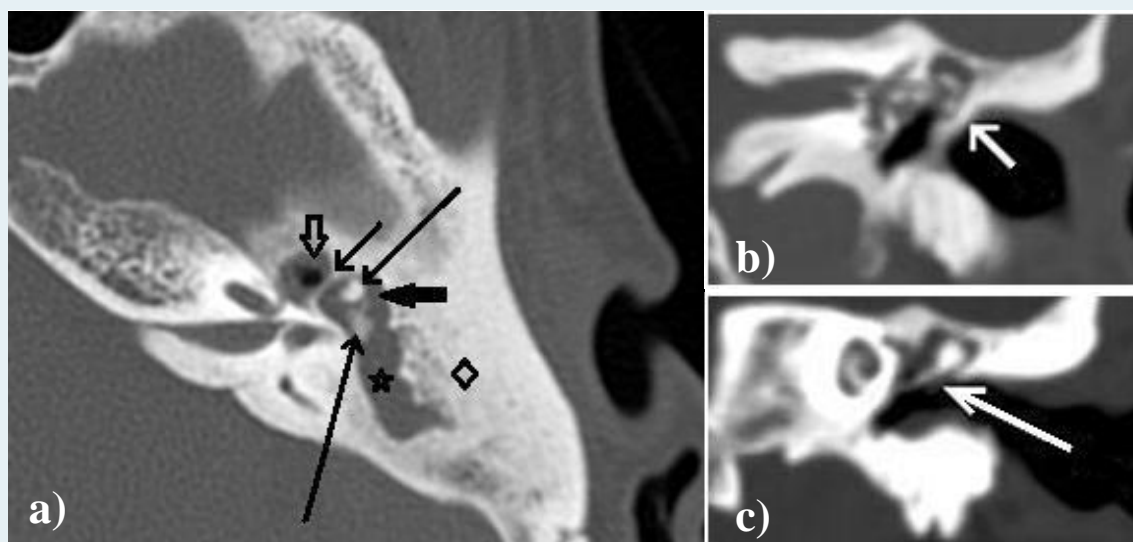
A. Axial Computed Tomography of the left middle ear demonstrating obliterative soft tissue density originating from left mastoid antrum [hollow star], travelling via aditus to the middle ear posterior epitympanum [solid short arrow] and completely obliterating it. This soft tissue density is partially delimited by the cog [short thin arrow] anteriorly resulting in only partial obliteration of the anterior attic [hollow short arrow]. Note the sclerotic mastoid [hollow diamond], intact head of malleus [intermediate thin arrow] and intact body and short process of incus [long thin arrow]. B. and C. Coronal views showing intact scutum [short white arrow] and intact body and long process of incus [long white arrow].
